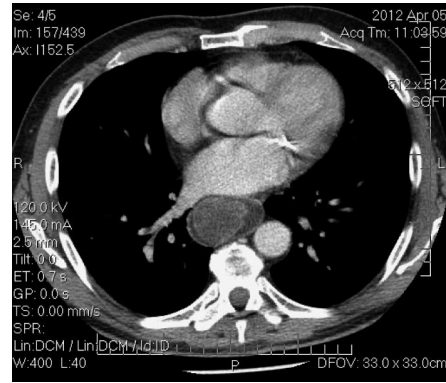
Computed tomography (mediastinal window setting) shows bulky neoformation jutting into the esophageal lumen.
